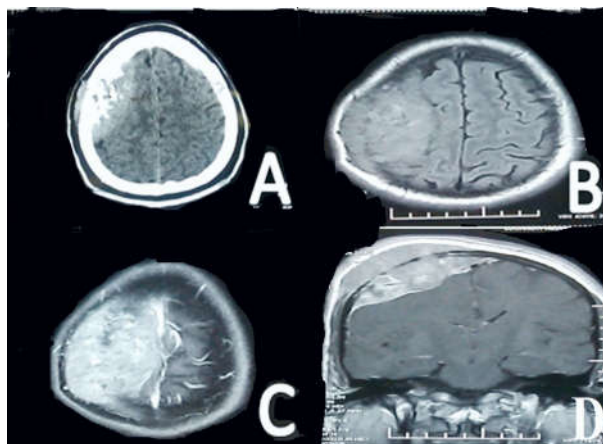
A. Plain CT showing hyperdense lesion with bony destruction in left frontoparietal region. B. T1W image showing isointense lesion. C. T1 contrast image showing brilliant contrast uptake. D. T1 coronal image showing transcalvarial extension of the lesion.
